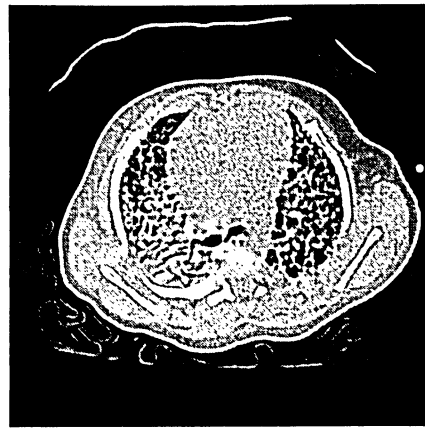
First row: Original Chest CT Image. Second Row: Segmented Lung with Watershed Transform. Third Row: Segmented Lung with Optimal Thresholding.
